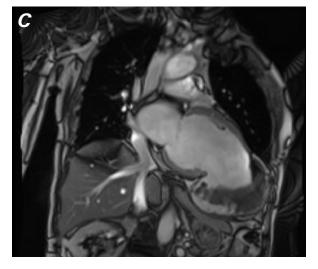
A) Transthoracic echocardiogram shows a small, narrow neck defect connected to the ventricle. B) Coronary angiogram shows multivessel coronary artery disease.
